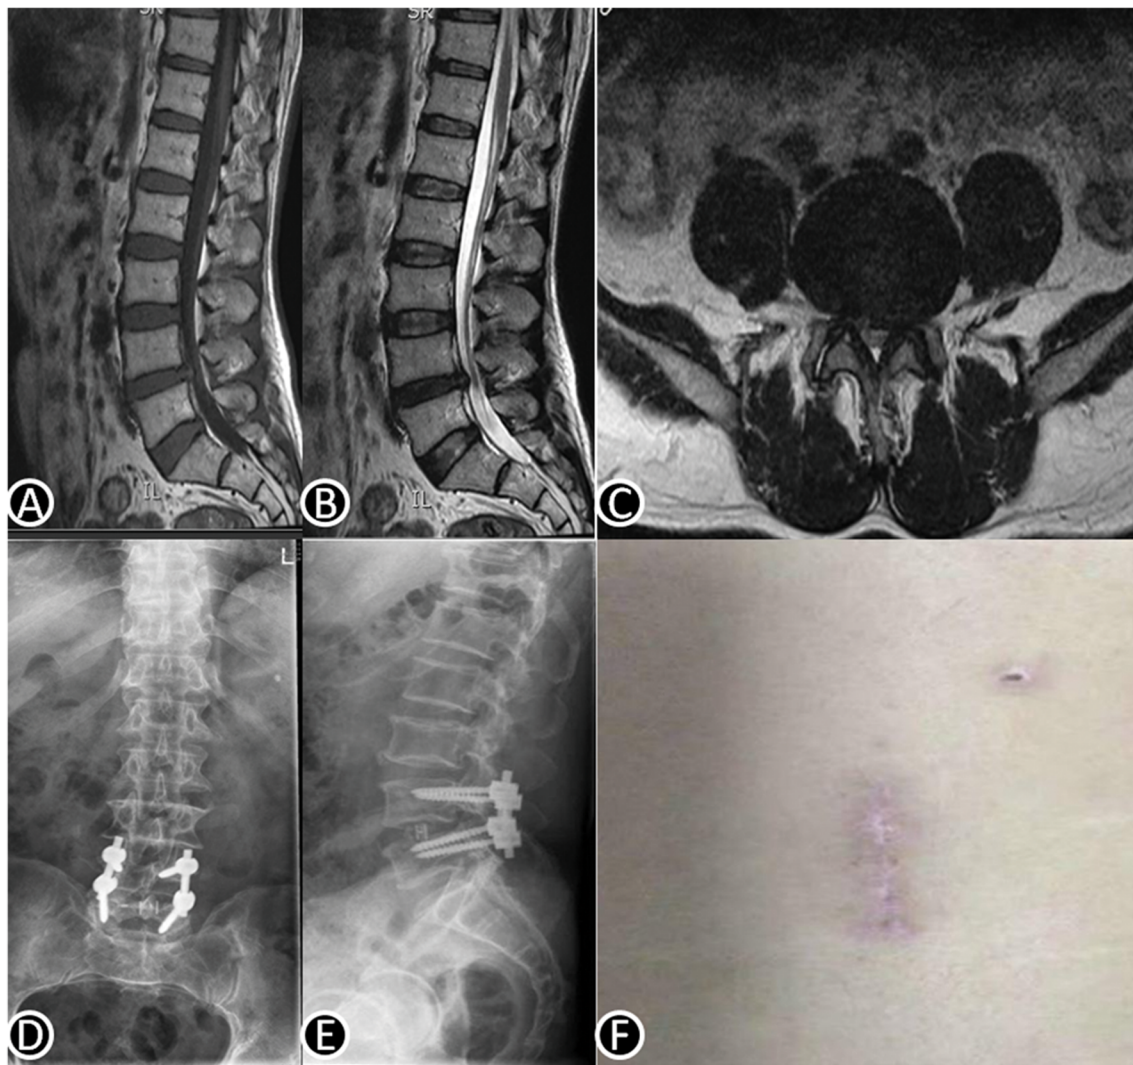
A 60-year-old female patient with low back pain and right leg pain. (A) Sagittal T1-weighted, (B) sagittal, and (C) axial T2-weighted MRI of a patient with severe L4–5 lumbar stenosis. (D, E) X-ray films after surgery. (F) The incision used to accomplish minimally invasive transforaminal lumbar interbody fusion (Mis-TLIF).
